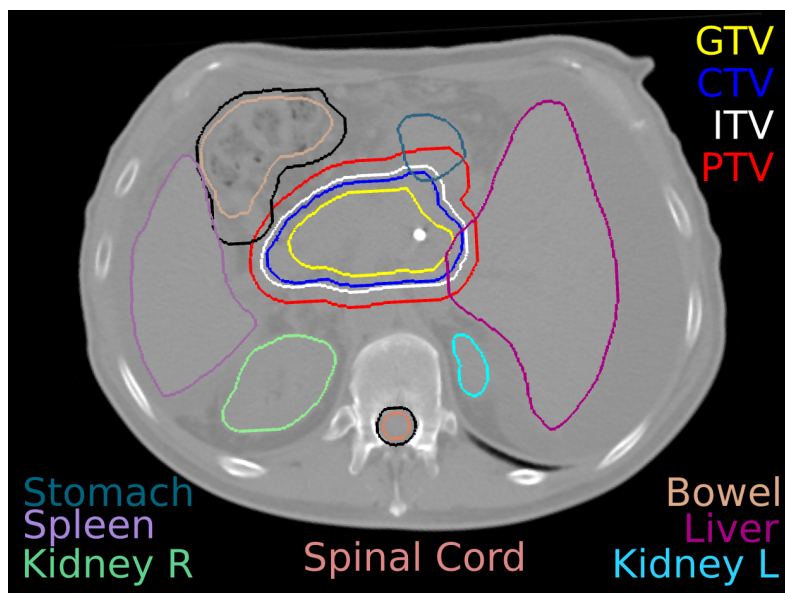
Transversal view of a CT of a patient showing the ICRU target concepts (GTV, CTV, ITV, PTV) and OARs. For the spinal cord and bowel is also shown the PRV (in black) used during the treatment planning to account for uncertainties.
